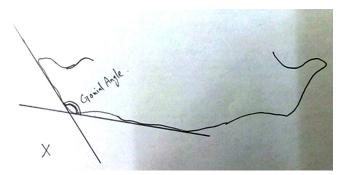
Gonial angle tracing on a Panoramic radiograph
